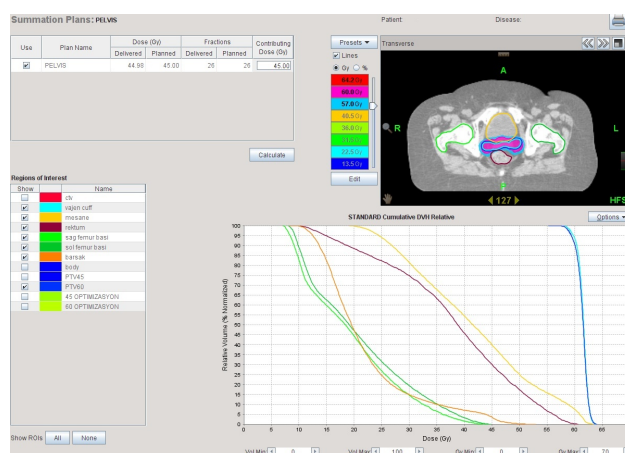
Endometrial Ca. Axial Image of the planning CT and Dose Volume Histogram (DVH).
